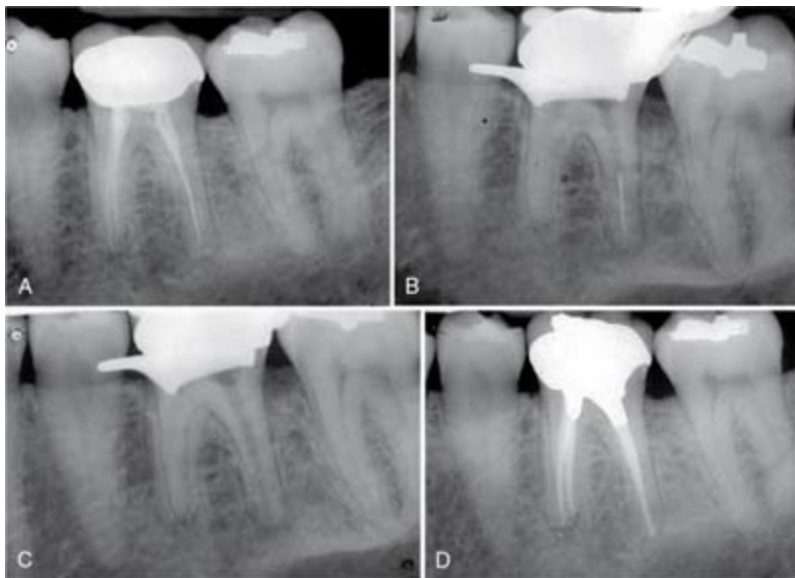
A, Preoperative radiograph of a tooth with symptomatic posttreatment disease. B, Although not readily apparent on the preoperative film, there is a separated nickel-titanium instrument in the distal canal. C, Check film showing that ultrasonics has removed the separated file. D, Thirteen-month recall film. The patient was asymptomatic.
